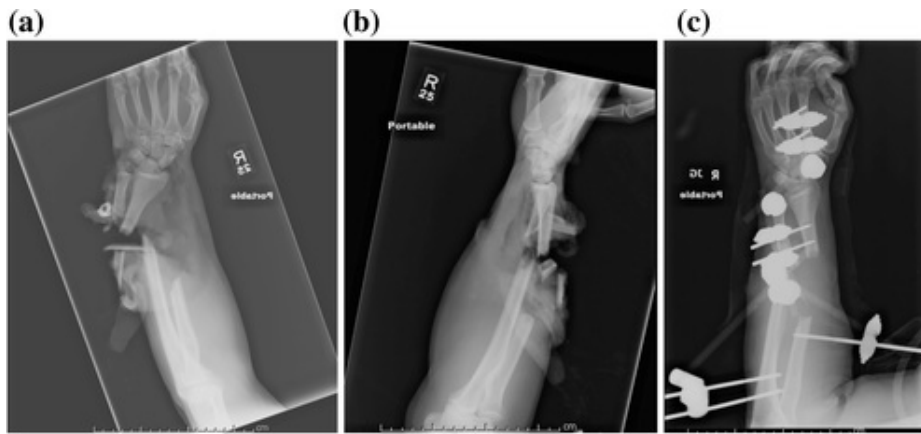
a, b *Anteroposterior* (AP) and lateral at initial injury showing obvious soft tissue defect and significant bony injury. c, d AP and lateral showing temporizing external fixation and the significant bone loss from the injury and after debridement. e, f AP and lateral after “bridging” internal fixation of wrist and open reduction internal fixation of radius and ulna. Cement spacer placed in radial defect. g Follow-up radiograph showing development of radioulnar synostosis. (h, i) AP and lateral of subsequent removal of hardware from ulna and Darrach procedure. j, k Final follow-up AP and lateral with healed ulna, stable radius with retained cement and establishment of radioulnar synostosis
